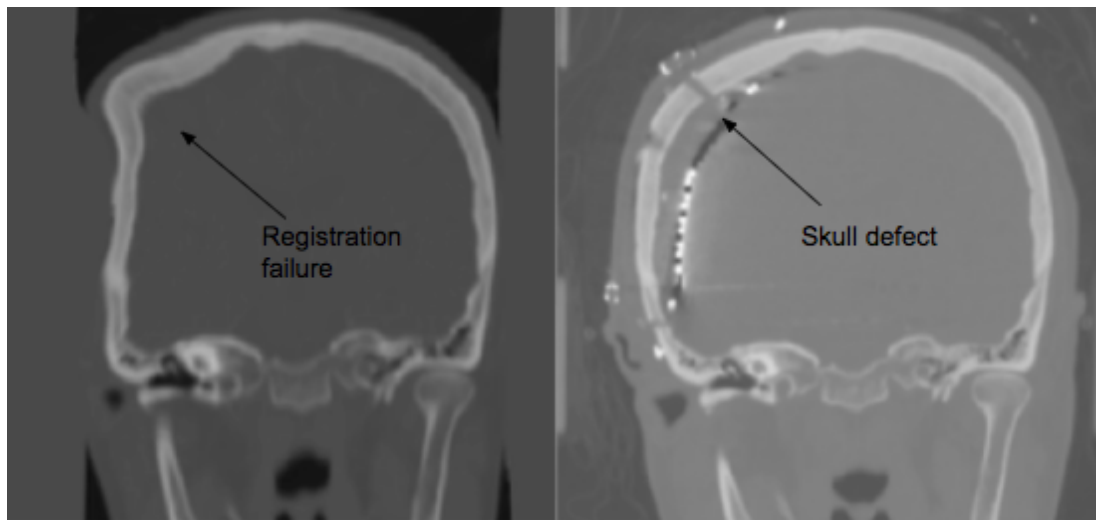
Registration failure resulting from skull defect. The left image shows a coronal slice of an output CT resulting from a nonrigid registration. The image on the right shows the same coronal slice on the post implantation CT that was used as the fixed image during the registration.
